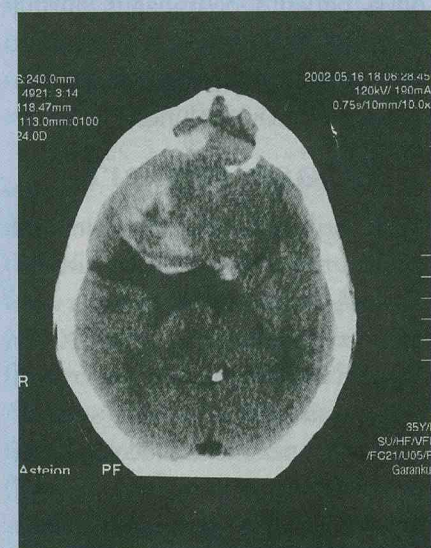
Axial CT scan, non-contrast, showing a tumour in the midfrontal lobe with calcifications, and moderate oedema and bone erosion.
